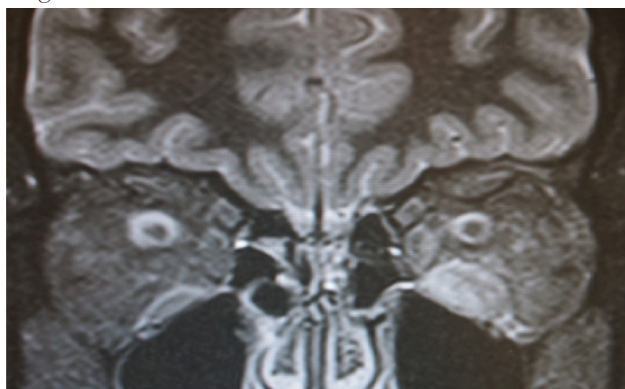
An MRI of the orbits revealed ill-defined enlargement of the left inferior rectus with surrounding fat infiltration. There was also increased enhancement of the left inferior rectus with apparent involvement of the distal myotendinous junction.
